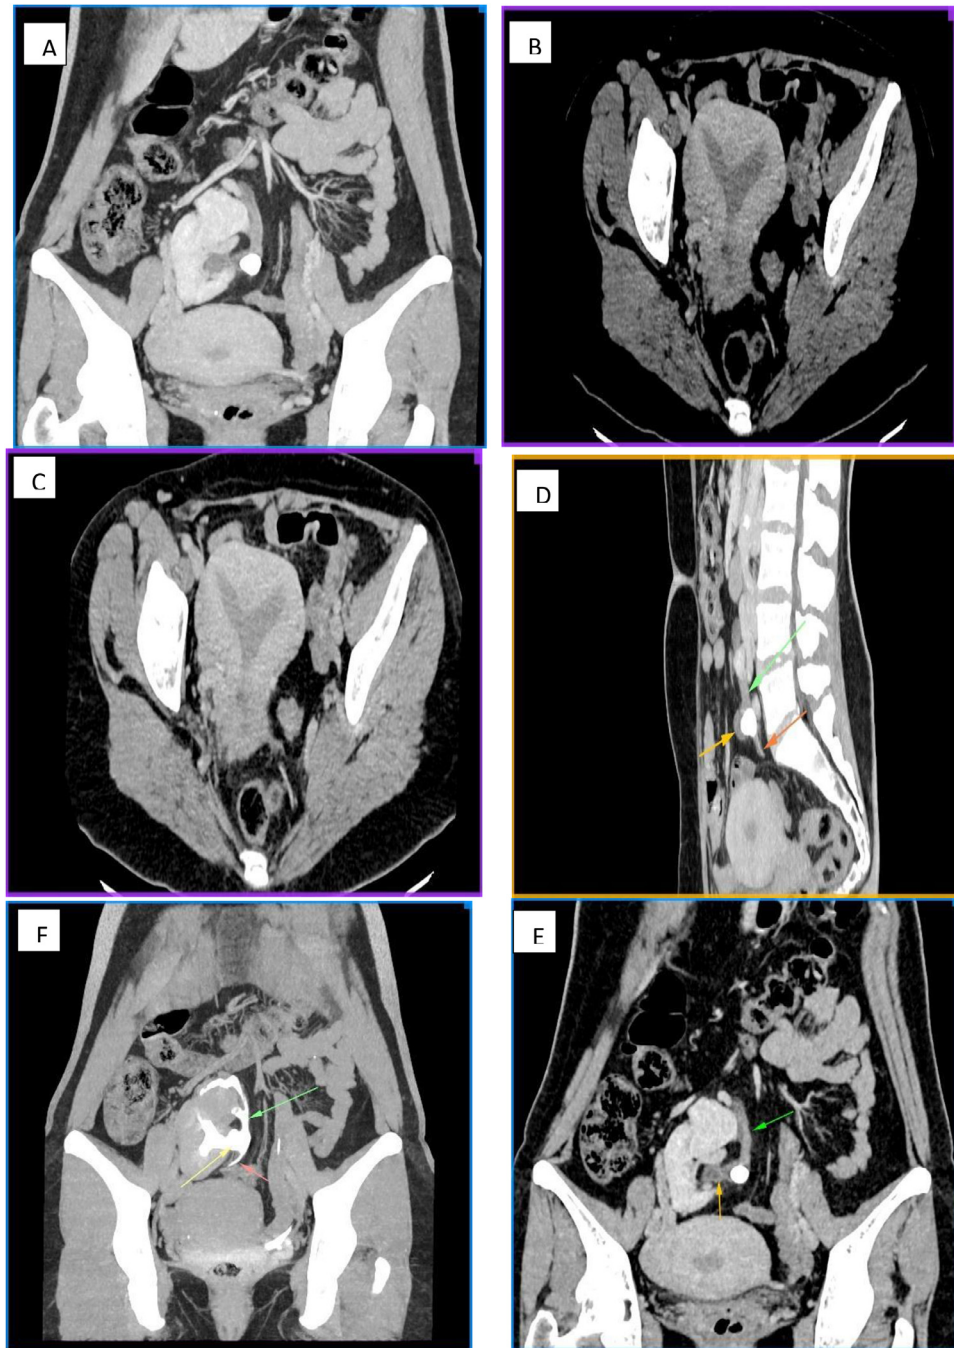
(A) CT urography coronal plane present: Ectopic and dysmorphic right kidney is seen, located in the right upper pelvic cavity. Double collecting system is evident with upper collecting system emerging from the upper pole. (B) Ct urography -MPR images axial plane present: Incidentally noted is the arcuate uterus, as an anatomical variant. (C) Ct urography -excretory phase axial plane present: Incidentally noted is the arcuate uterus, as an anatomical variant. (D) CT urography excretory phase sagittal plane present: located where the two collecting systems merge is a non-obstructive but large calculus in the right renal pelvis, just proximal to the upper ureter. The calculus is obscured in the contrast excretory phase. (E) CT urography excretory phase coronal plane present Double collecting system single ureter. (F) CT urography excretory phase coronal plane present: There is single ureter, despite the double collecting system. Barely enough total ureter length to join urinary bladder makes this an ectopic kidney case, rather than a mobile kidney where the ureter is usually longer with folding to adjust the kidney mobility between right upper quadrant and pelvic cavity.
